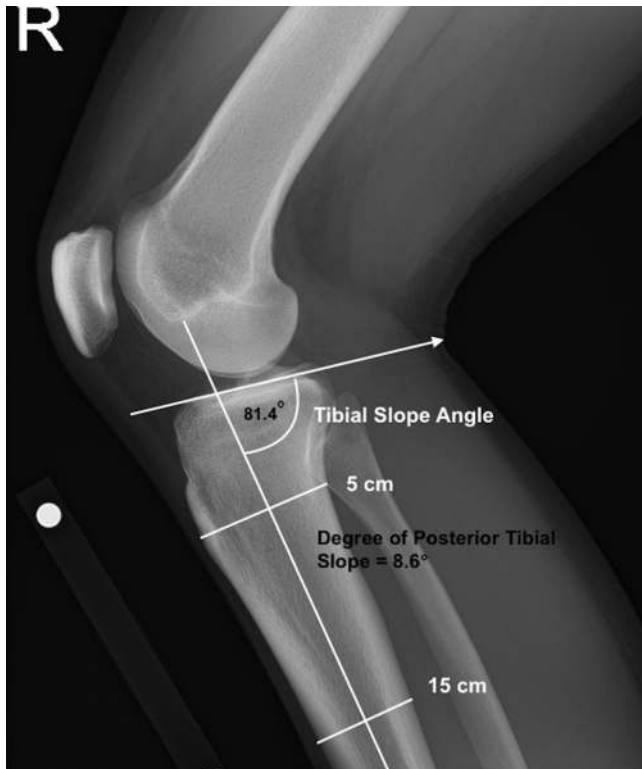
Lateral radiograph demonstrating described technique for calculating sagittal plane tibial slope. The resultant tibial slope angle was subtracted from 90° to determine the posterior tibial slope (in degrees).
